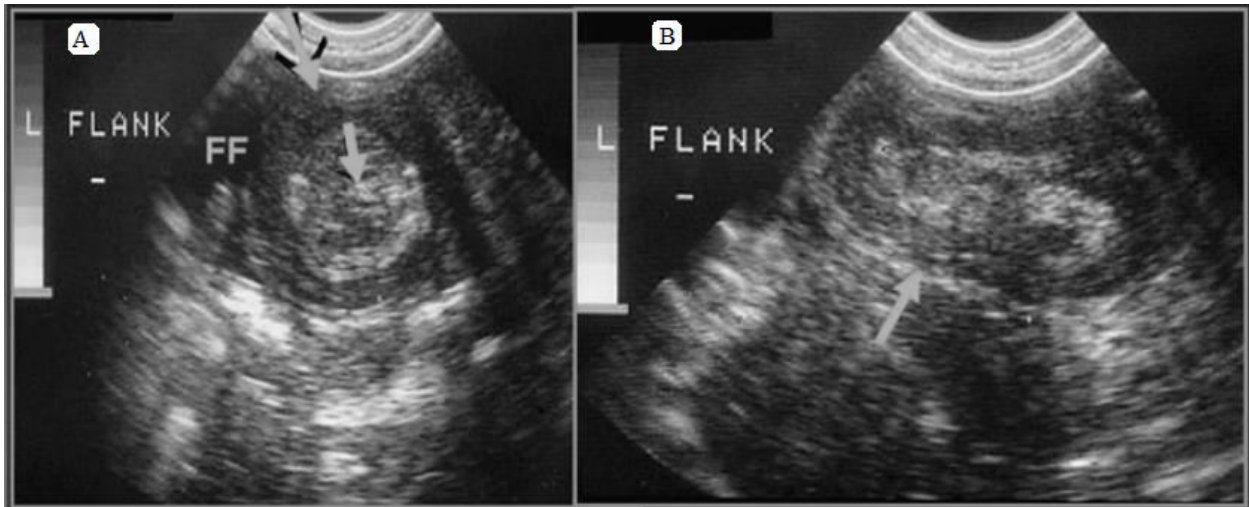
Ultrasound diagnosis of intussusception. The first part of the figure demonstrates the target or double donut sign with the inner ring representing the intussusceptum and the outer ring representing the intussusciens (larger arrow). The central dot represents mucus lining the lumen of the inner ring (smaller arrow). FF indicates free fluid.
